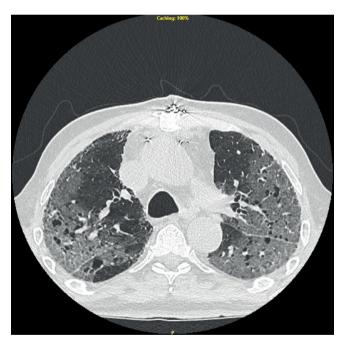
Chest CT scan of the patient 4 days after CABG with signs of pneumonia.
